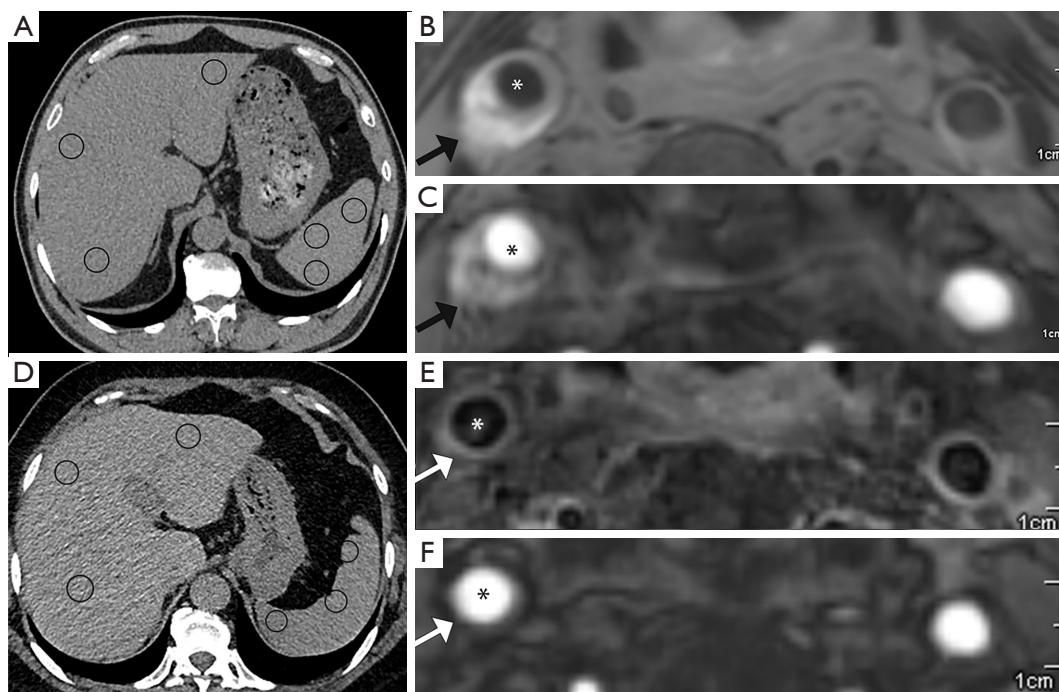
Analysis of carotid plaques in patients with and without NAFLD. (A) Diffuse fat accumulation was observed in a liver in an unenhanced CT image with a liver/spleen ratio of 0.81; (B) axial T1WI clearly showed the hypersignal of IPH (black arrow); (C) axial 2D-TOF showed IPH with a hypersignal (black arrow). (D) Diffuse fat accumulation was observed in a liver in an unenhanced CT image with a liver/spleen ratio of 1.12; (E) axial T1WI clearly showed the absence of IPH (white arrow); (F) axial 2D-TOF showed the absence of IPH (white arrow). (o) indicates the measurements of mean CT values of the liver/spleen; (*) indicates the lumen of the carotid artery. NAFLD, non-alcoholic fatty liver disease; CT, computed tomography; T1WI, T1-weighted imaging; IPH, intraplaque hemorrhage; TOF, time-of-flight.
